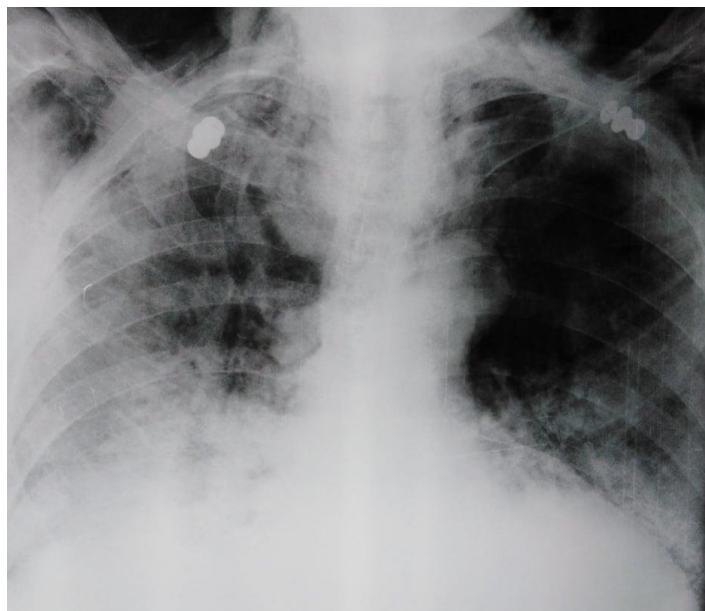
Chest x-ray done in a patient with acute respiratory distress syndrome raising suspicion of pneumothorax. We also note the presence of thoracic subcutaneous emphysema bilateral
